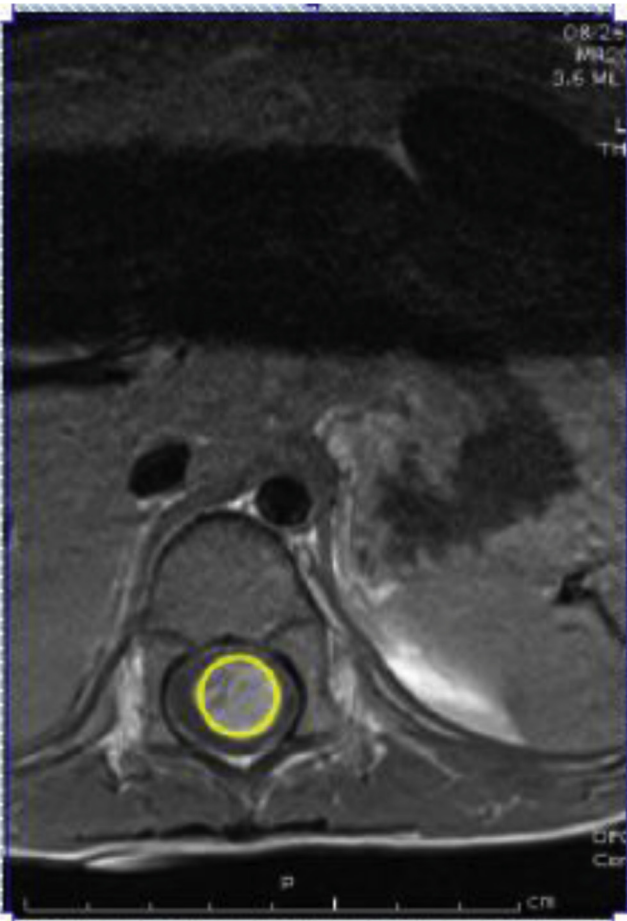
Initial axial T1 MRI showing tumor and enlarged spinal cord (yellow circle).
